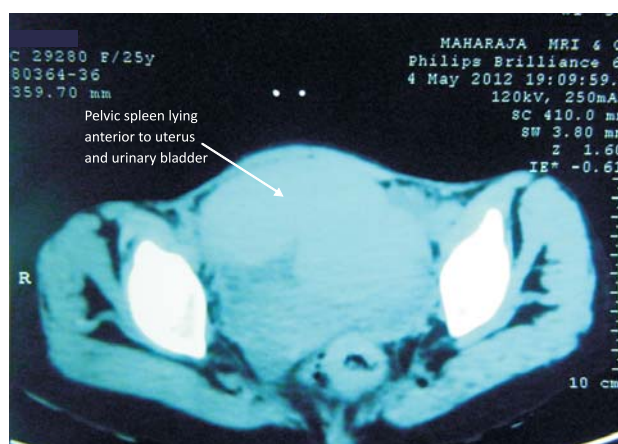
CT abdomen showing pelvic spleen lying anterior to uterus and urinary bladder.
